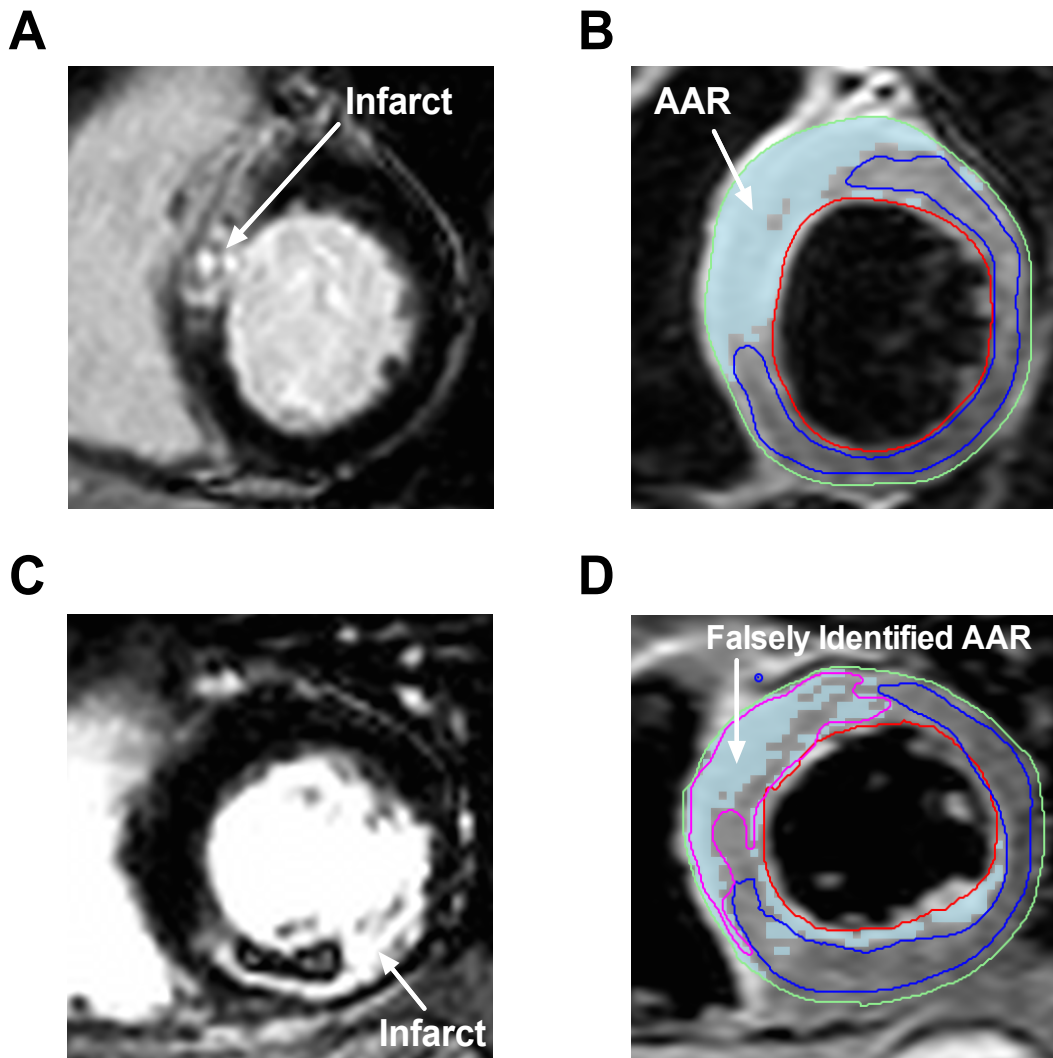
Technical issues with area at risk and salvage index quantification. A+B: Corresponding LGE and T2-weighted STIR images respectively for an anteroseptal STEMI. The region of infarction is indicated by the white hyperenhanced area in A, while the corresponding AAR is indicated by light blue shading in the analysed image in B. C+D show corresponding LGE and T2-weighted STIR images respectively for an inferior STEMI with extensive MVO. The region of infarction is indicated by the hyperenhanced area in C, with a hypoenhanced zone (MVO) within core of the infarct. In the analysed STIR image (D), however, the analysis software has misidentified the AAR, due to comparatively stronger signal from the anterior wall, making salvage index quantification unreliable.
